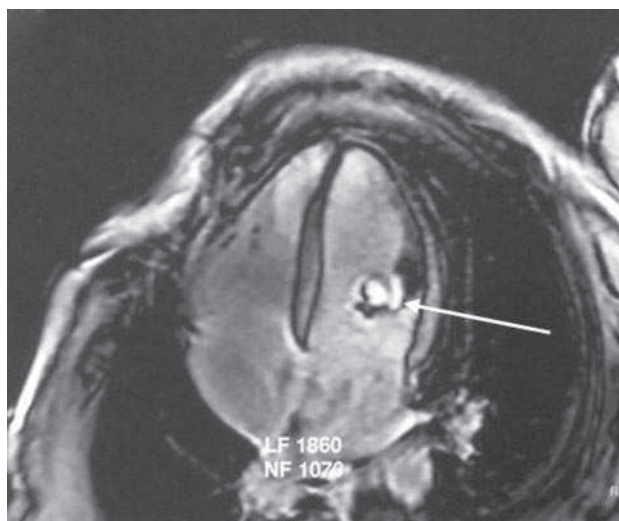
Magnetic resonance imaging with an enhancing cystic lesion fixed on the anterior papillary muscle.
